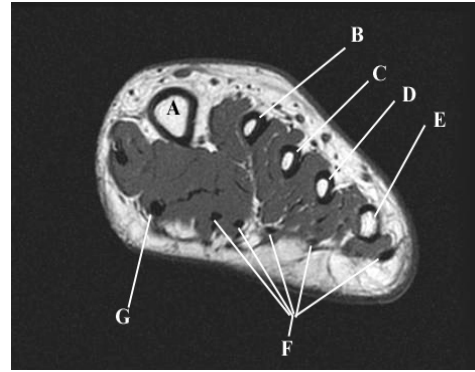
T1-weighted short axis of foot through metatarsals. A-1st metatarsal, B-2nd metatarsal, C-3rd metatarsal, D-4th metatarsal, E- 5th metatarsal, F- flexor digitorum tendons, G- flexor hallucis longus tendon*
